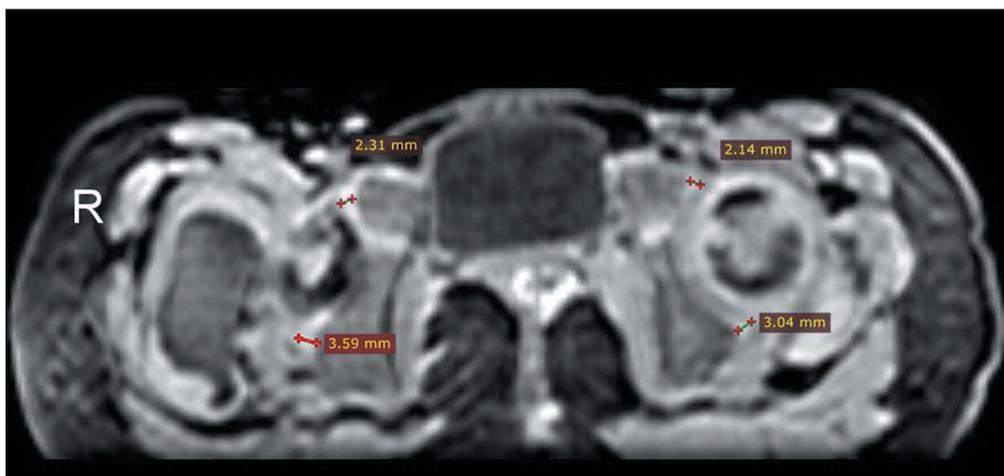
Axial 3D SPGR MRI sequence showing the cartilage thickness at the anterior and posterior rims of the acetabulum. The right hip (R) is dysplastic, and the left hip is normal. The femoral neck on the right side is at the same level as the femoral head on the left side, due to superior displacement of the dislocated femur on the right (dysplastic) side.
